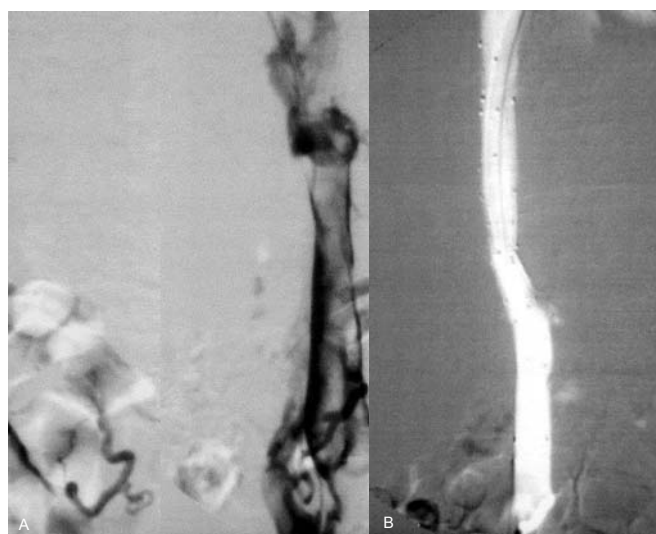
73-year-old male with known hepatic polycystic disease presented with swelling of both lower limbs and ascitis. CT (not shown) evidenced compression and thrombosis of the IVC by polycystic hepatomegaly.
